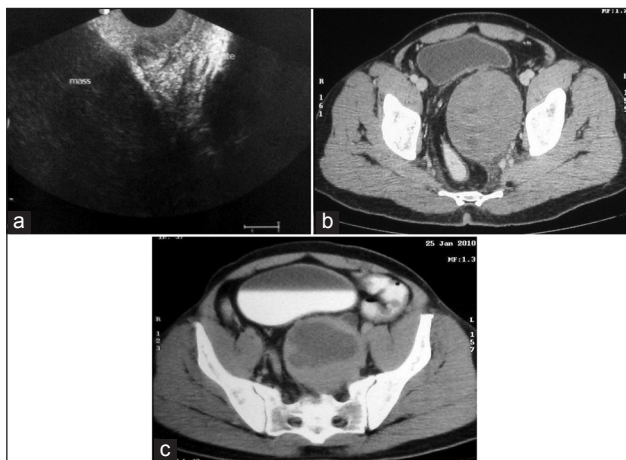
(a) Transrectal ultrasonography of pelvis showing the homogeneous well-defined hypoechoic mass at the base of the bladder separate from the prostate. Left seminal vesicle was not seen separately. (b and c) Contrast enhanced computed tomography scan depicts a large mass lesion with predominantly solid densities displacing the urinary bladder and prostate, with moderate enhancement
